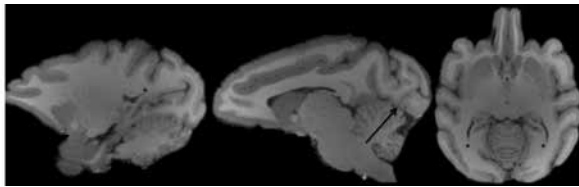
Normal occipital horn configuration on MRI. Two sagittal slices and an axial slice of a 3D, T1-weighted MRI study. The black arrow indicates the landmark for differentiating occipital horn elongation (mesio basal onset of the calcarine sulcus). Black asterisks indicate the occipital horns.
